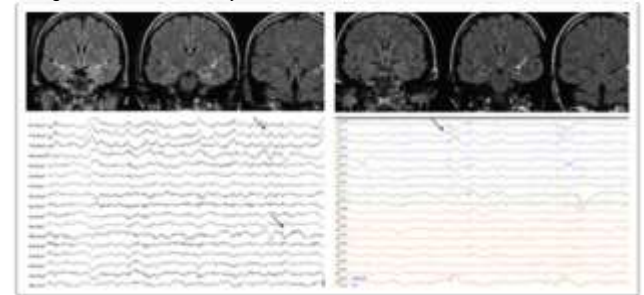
Autoimmune encephalitis presentation through MRI and EEG and changes involved shown by arrows
